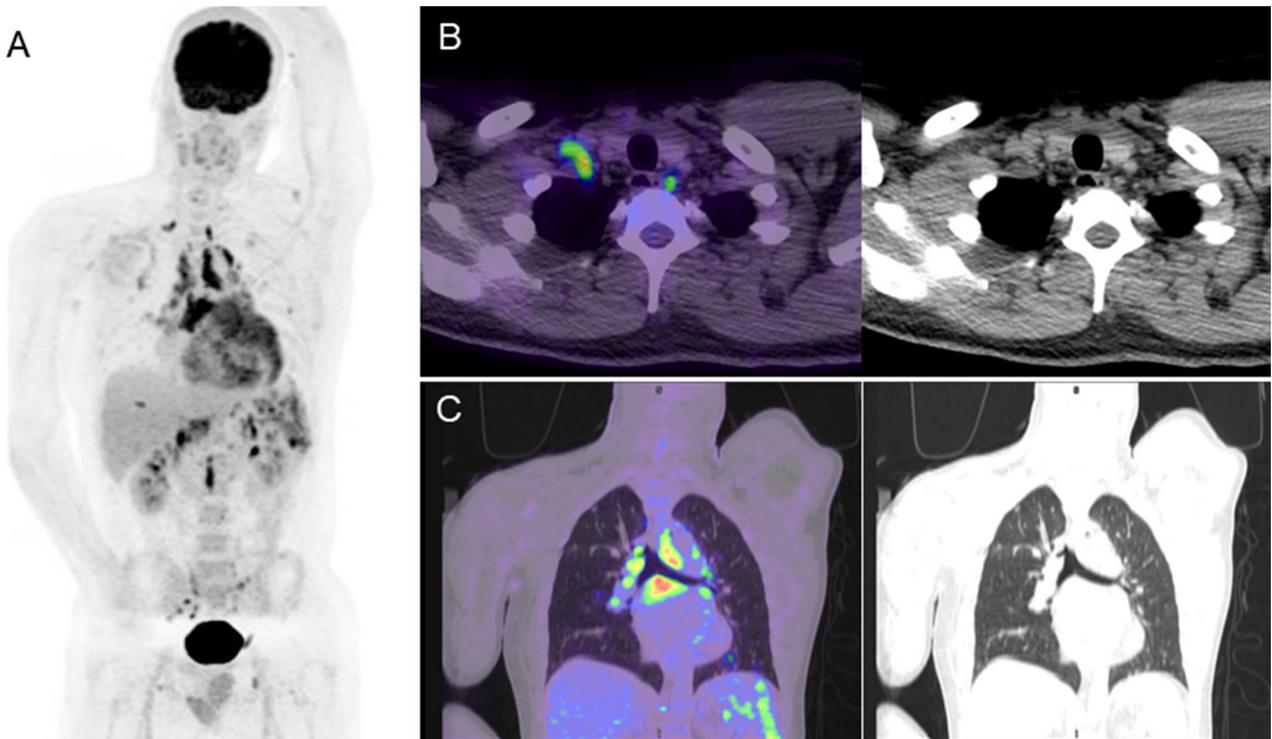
Whole body PET/CT. The patient underwent a 48-hour high-fat, low-carbohydrate diet, followed by 12 hours of fasting and 2500 units of IV heparin prior to Fluorodeoxyglucose (FDG) administration. The maximum intensity projection (A) demonstrated abnormalities in a biodistribution characteristic of active sarcoidosis including high-intensity metabolic activity in supraclavicular, mediastinal, and paraaortic nodes. There was also focal uptake in pulmonary opacities and multifocal abnormalities in the spleen and myocardium. B, C demonstrate representative axial (B) and coronal (C) PET-CT slices.
